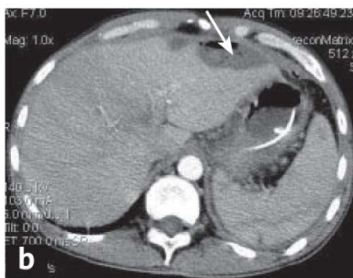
Spiral computed tomography of the abdomen: *a* – drained abscess of the pancreatic body and omental bursa; *b* - undrained abscess of the subdiaphragmatic space
